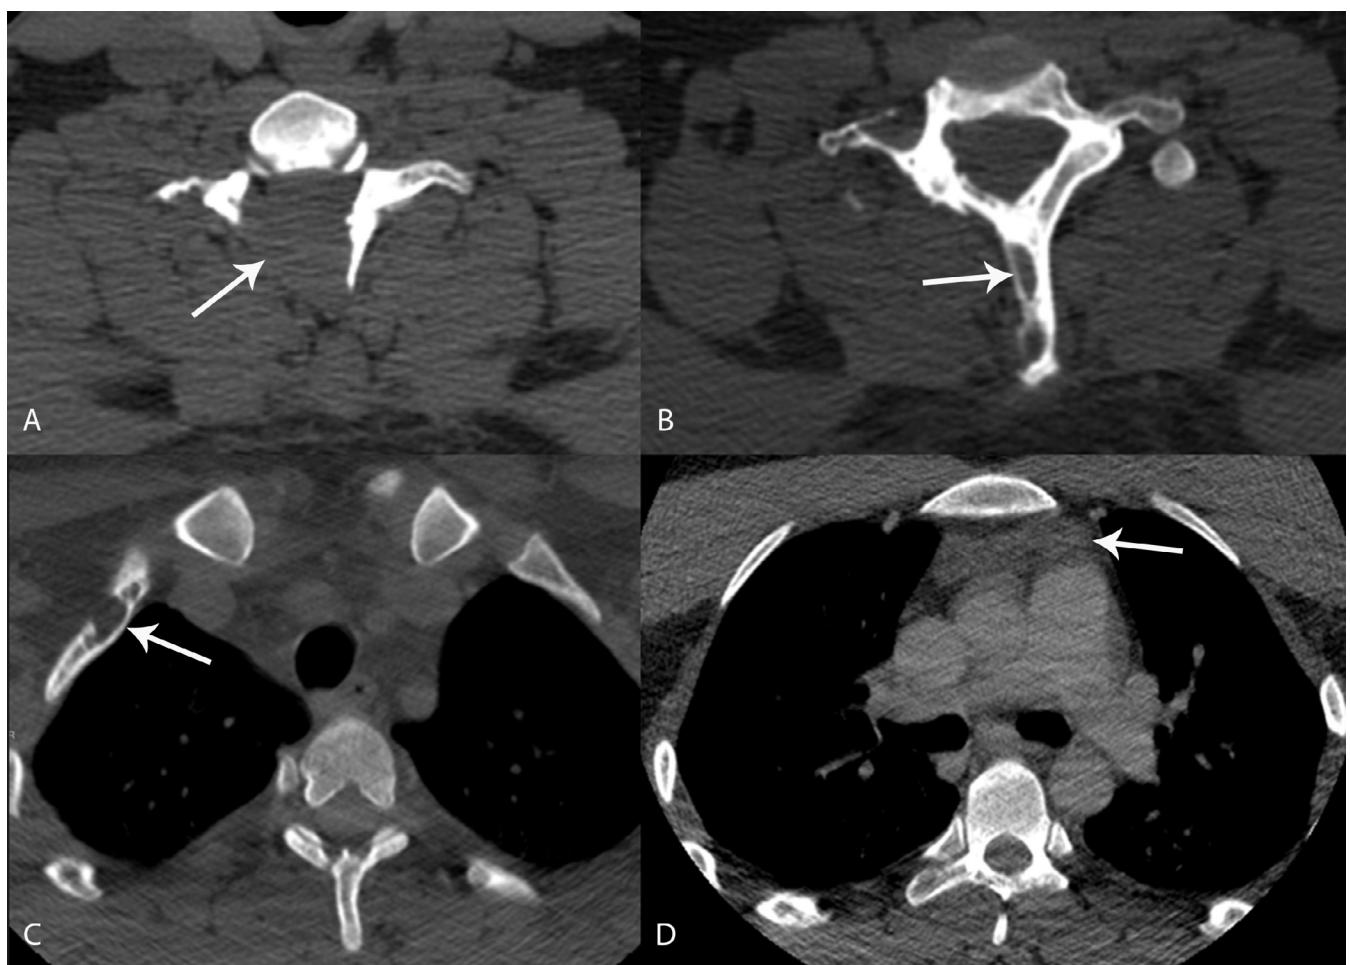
Axial CT scans showed a destructive vanishing bone tumor in the C6 vertebra (A), lucent lesions in the T1 vertebra (B), and second right anterior costa (C) (arrows). Fat density in the second right anterior costa lesion suggested benignity. A very low density mass compatible with lymphangioma was found in the anterior mediastinum (D) (arrow).
